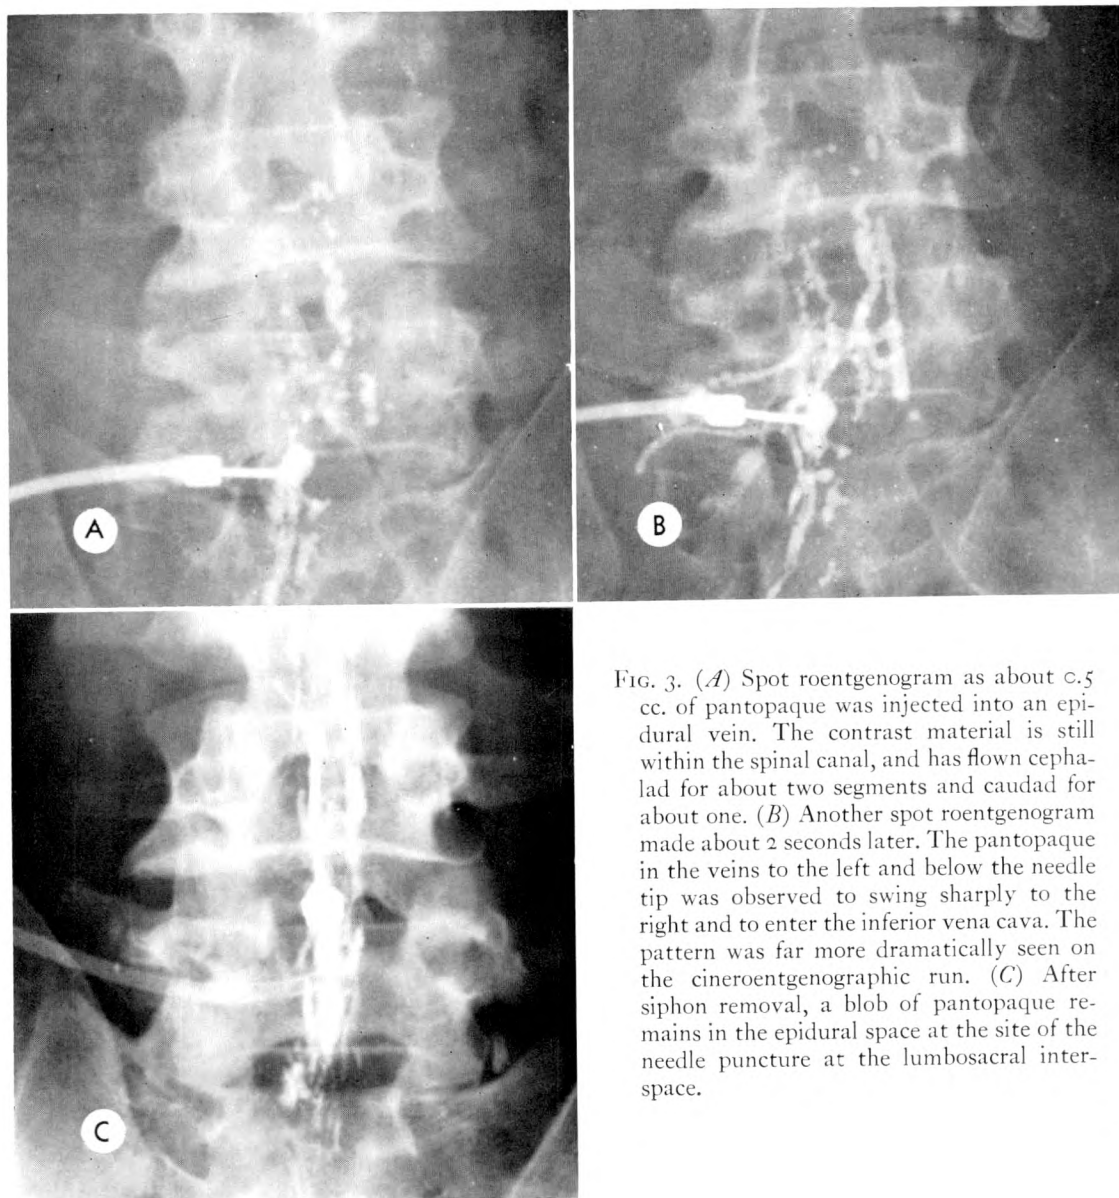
(A) Spot roentgenogram as about c.5 cc. of pantopaque was injected into an epidural vein. The contrast material is still within the spinal canal, and has flown cephalad for about two segments and caudad for about one. (B) Another spot roentgenogram made about 2 seconds later. The pantopaque in the veins to the left and below the needle tip was observed to swing sharply to the right and to enter the inferior vena cava. The pattern was far more dramatically seen on the cineroentgenographic run. (C) After siphon removal, a blob of pantopaque remains in the epidural space at the site of the needle puncture at the lumbosacral interspace.
